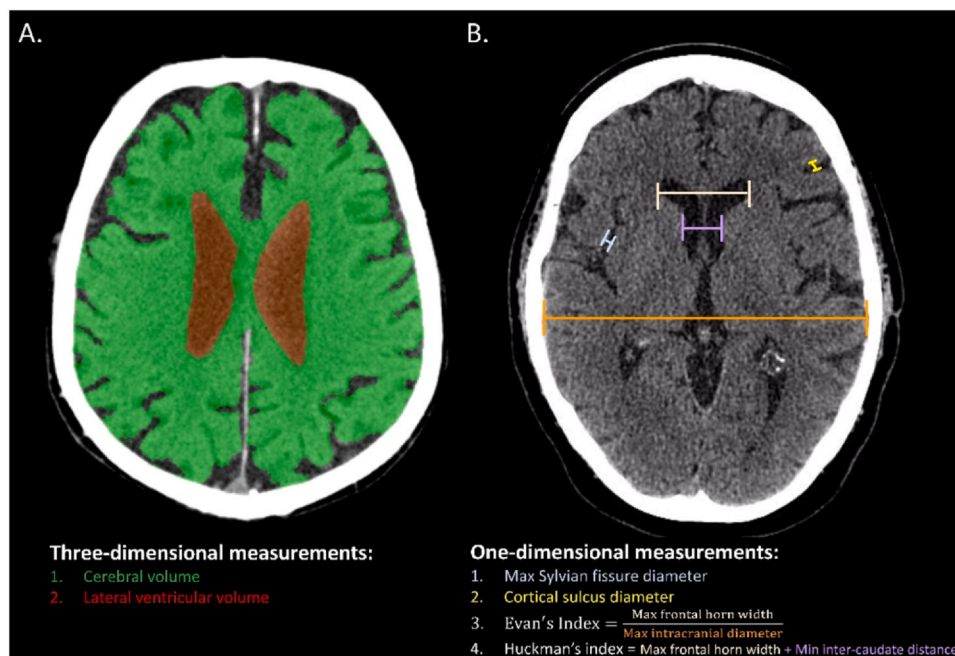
Neuroimaging Volumetrics: CT imaging depicts (A) manual segmentation of cerebral volume (green) and lateral ventricular volume (red), performed in ITK-SNAP. A single axial section is depicted, but the manual segmentation was performed on every section to facilitate a 3-dimensional volumetric analysis. (B) One-dimensional surrogate metrics of brain volume were also assessed in the axial plane. Each metric is indicated by color coded bars and corresponding text below the image.
